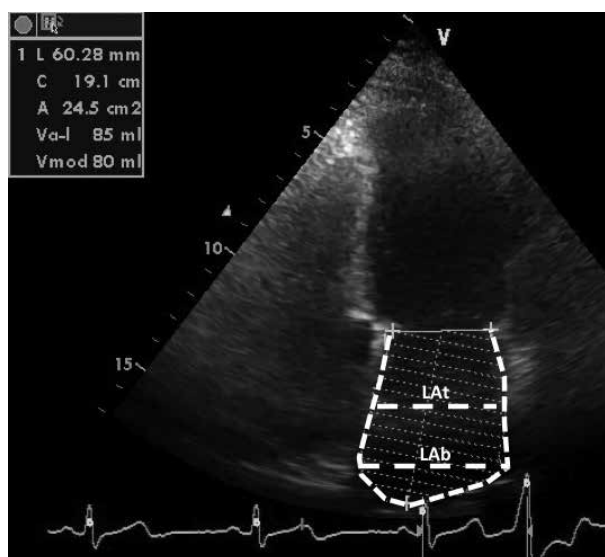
Left atrium (LA) size and shape assessment in studied patients. Both mid-LA transverse diameter (LAT) and basal LA diameter (LAB) were measured in apical four-chamber view at end-systole just before mitral valve opening. The trapezoid LA shape is defined by $\text{LAT} < \text{LAB}$
